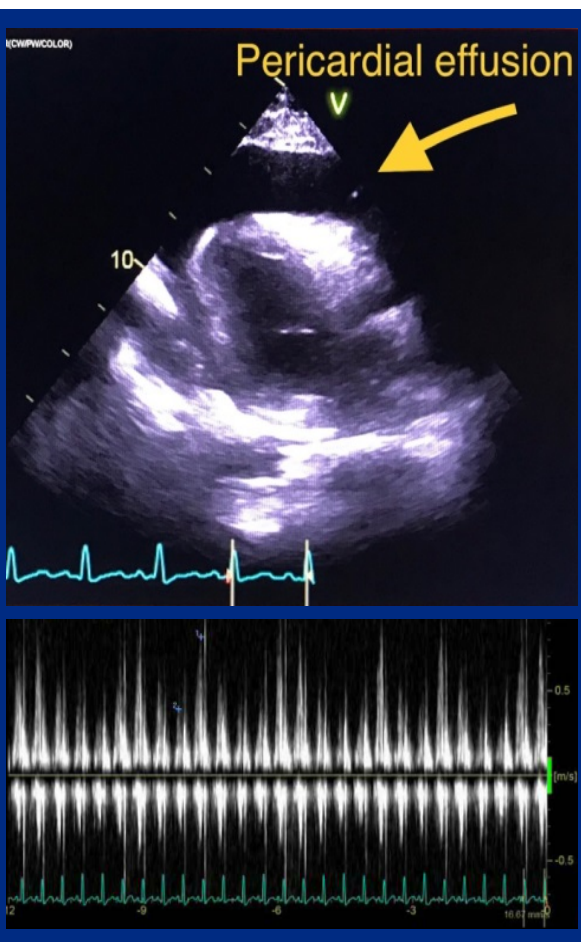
Top: 2-dimensional transthoracic echocardiogram (2-D TTE) demonstrating large pericardial effusion. Bottom: tricuspid inflow variation indicative of tamponade physiology.
